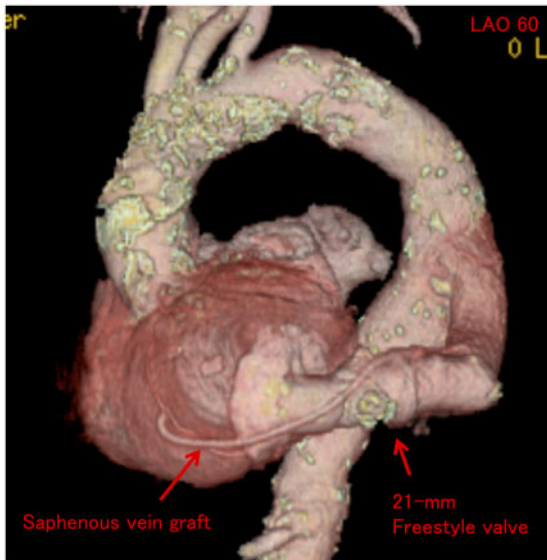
A computed tomography angiography (left anterior oblique 60° projection) showing the apico-aortic conduit that connects the left ventricular apex directly to the descending aorta and patent saphenous vein graft from the conduit to the left anterior descending artery.
